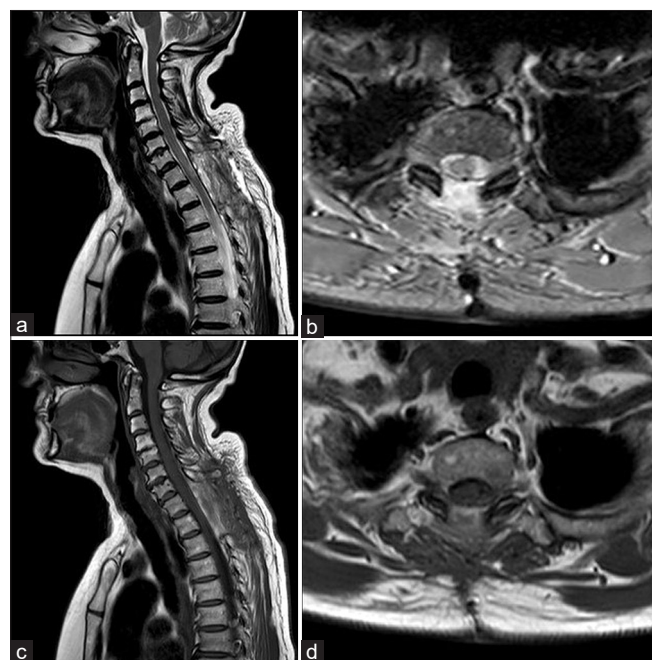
MRI of the cervical and proximal thoracic spine after surgical evacuation of the collection. Sagittal T2WI (a), axial T2WI (b), sagittal T1WI (c), and axial T1WI (d). The collection has been completely removed, there is almost complete re-expansion of the spinal cord.
